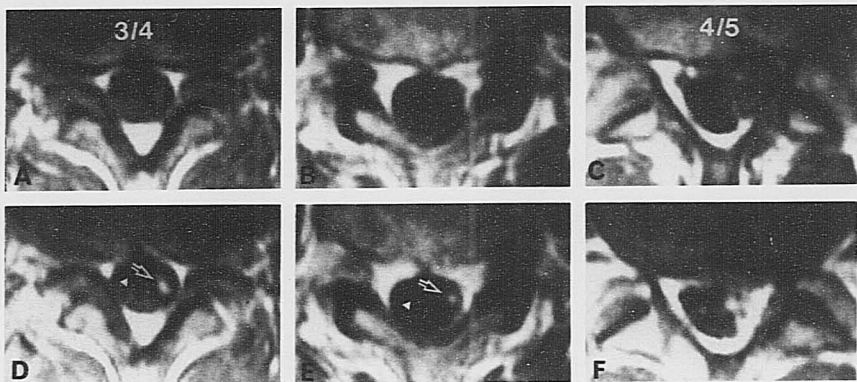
A 48-year-old man with herniation of L4/5 intervertebral disc in the left side. He had severe sciatic pain projecting into the lateral aspect of the leg, limitation of SLR ( $40^\circ$ ), and moderate dysfunction of L5 nerve root in the left side. A–C: Nonenhanced T1-weighted images. D–F: Enhanced MR images depict the affected left L5 nerve root with enhancement (arrow). A small enhanced signal observed in the opposite side is thought to be that of a radicular vein (arrow head).
